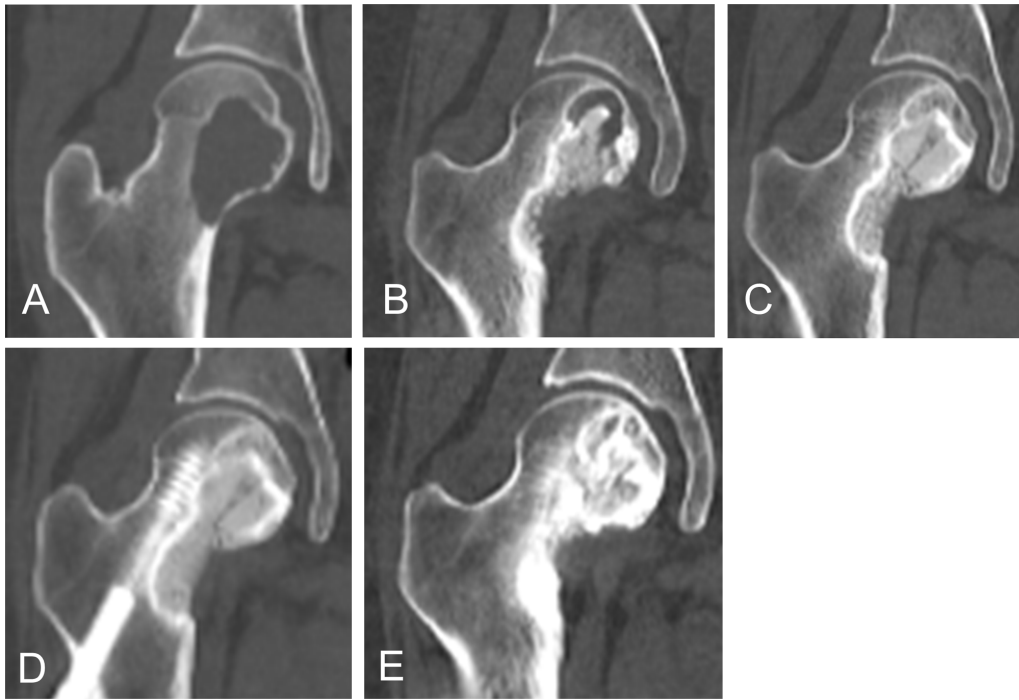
A 26-year-old woman with GCTB in the femoral head. (A) CT images showed a lytic lesion. She underwent two rounds of curettage and bone grafting with internal fixation. (B) CT image showed a lytic lesion in the femoral neck. (C) Denosumab treatment was initiated. After 4 months, sclerosis change was confirmed. (D) After 10 months, the lytic lesion was filled with newly formed bone. Then, 24-weekly denosumab treatment was administered. (E) At the last follow-up, the patient showed stable disease. GCTB, giant cell tumor of bone; CT, computed tomography.
